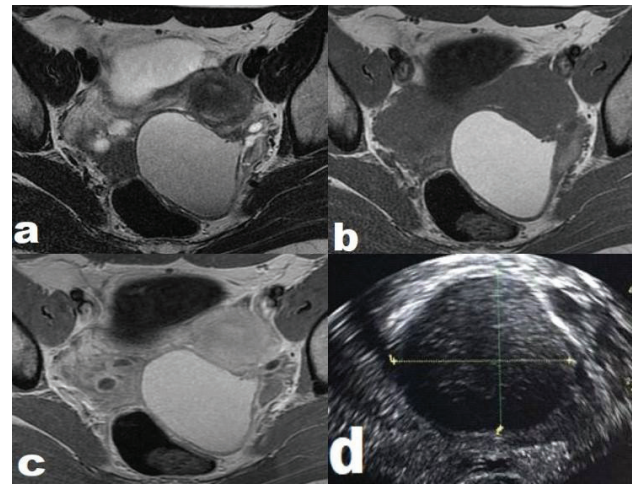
MRI and TVU images of the hemorrhagic cyst of the left ovary
